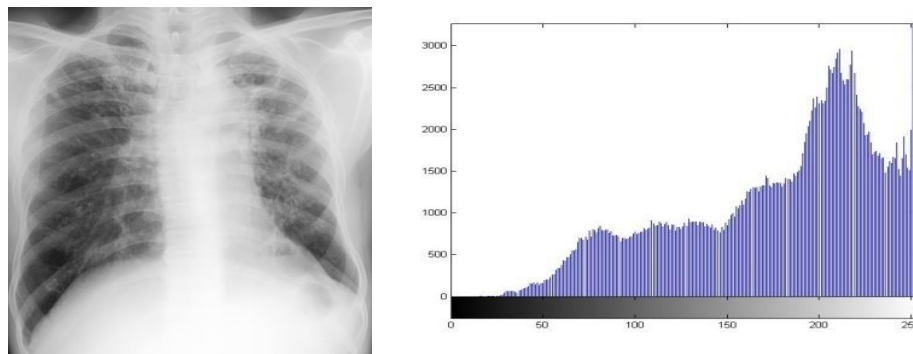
(a) abnormal Xray (b). histogram of abnormal Chest X-ray
